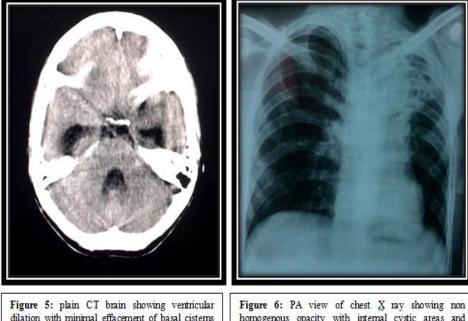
plain CT brain showing ventricular dilation with minimal effacement of basal cistems suggestive of non obstructive hydrocephalous in a patient of tubercular meningitis
